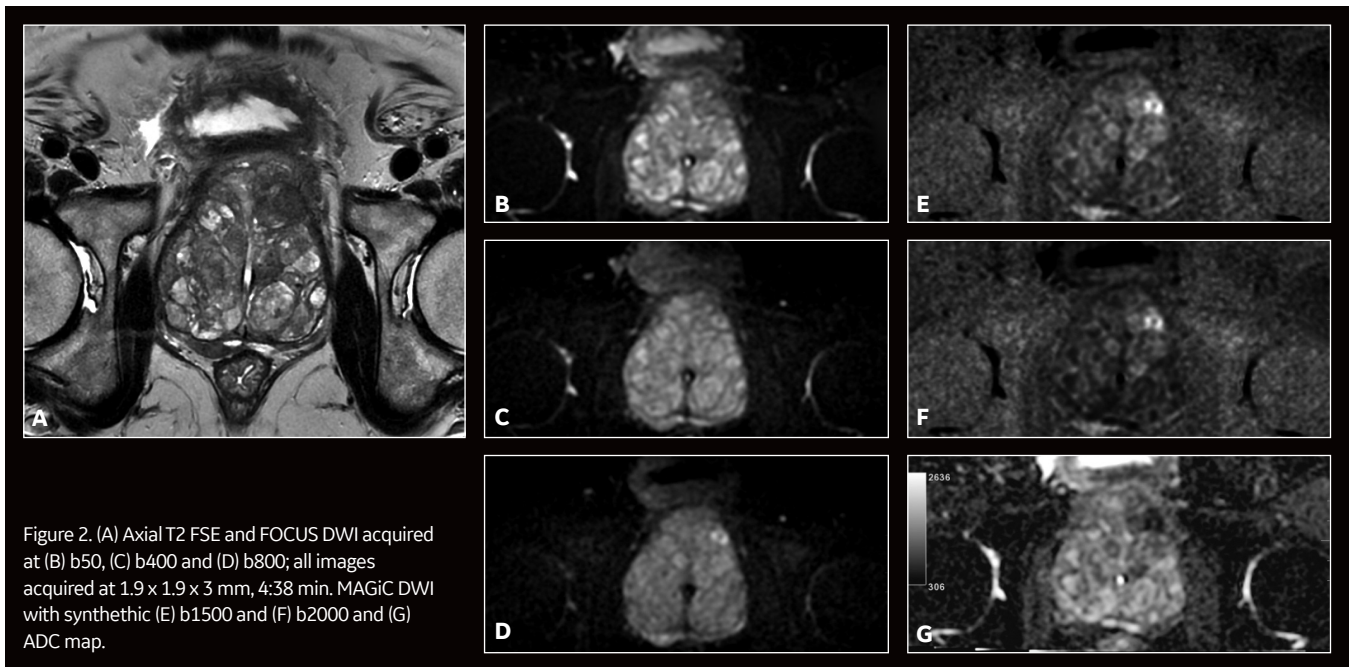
(A) Axial T2 FSE and FOCUS DWI acquired at (B) b50, (C) b400 and (D) b800; all images acquired at $1.9 \times 1.9 \times 3$ mm, 4:38 min. MAGiC DWI with synthetic (E) b1500 and (F) b2000 and (G) ADC map.
